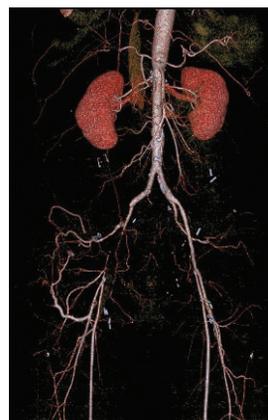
Three-dimensional volume rendering of reconstructed CT angiogram of a 57-year-old woman with ischemic rest pain in the right leg, demonstrating chronic occlusion of the right common and external iliac and common femoral arteries. The patient had previously undergone (failed) endovascular intervention and cross-over left-to-right femoral-femoral artery bypass.
